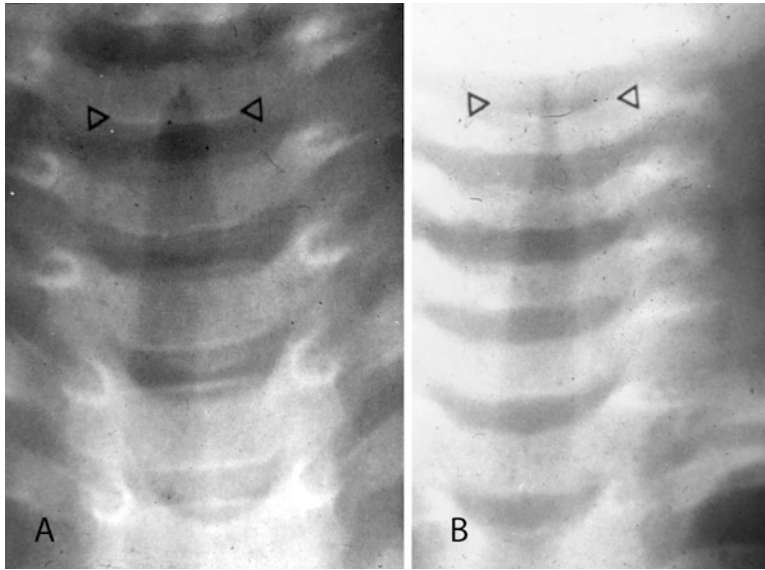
Plain X-ray of the airway of a child with severe croup (a) and mild croup (b). Note the subglottic narrowing and appearance of the characteristics “Chrysler
